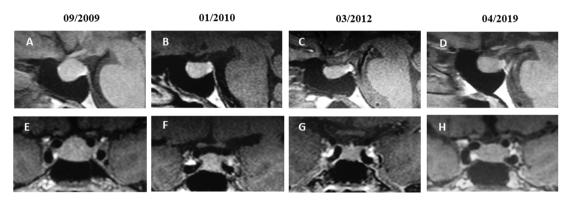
The magnetic resonance images of the pituitary gland exhibiting pituitary mass shrinkage in sagittal and coronal views. (A and E) Before treatment. (B and F) After somatostatin analogue treatment started. (C and G) Under treatment before increase in prolactin levels. (D and H) Under treatment with elevated prolactin levels.
